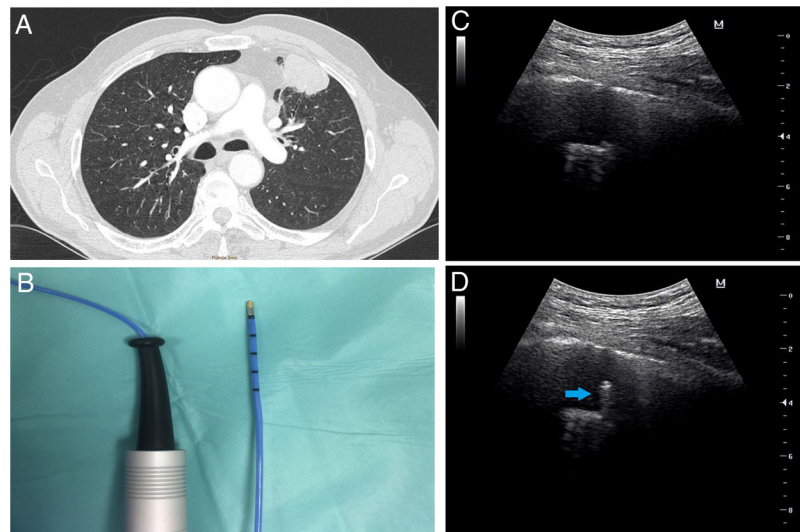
(A) Chest CT image shows a lingular mass with pleural contact and bronchus sign. (B) Flexible cryoprobe indicated for transbronchial biopsy. Outer diameter 1.9 mm, length 900 mm. (C) Transthoracic ultrasound image before performing transbronchial biopsy of the mass. (D) Transthoracic ultrasound image during the performance of transbronchial biopsy, which locates the cryoprobe within the lung mass (arrow).
